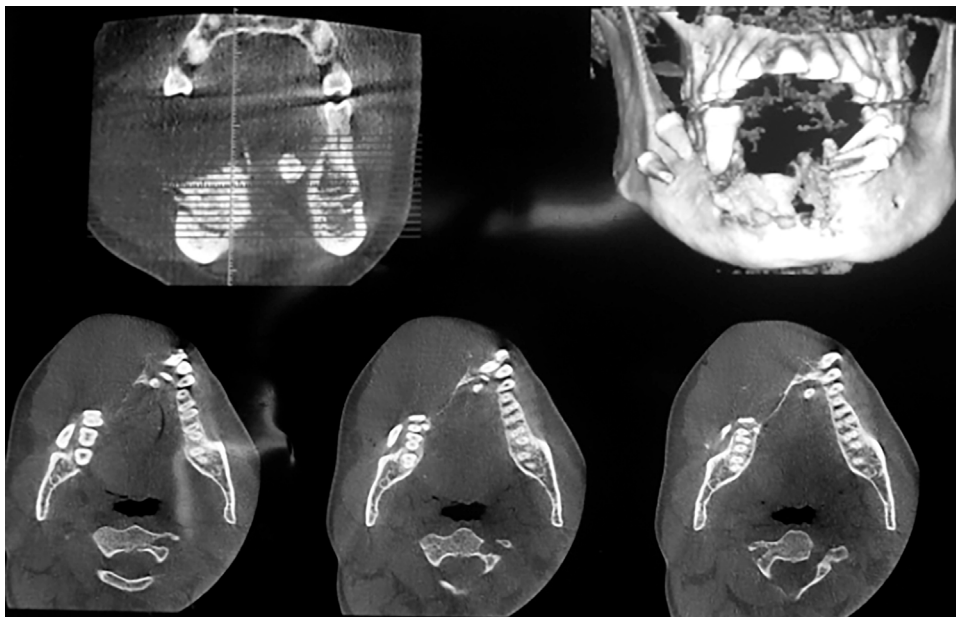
The CBCT scan revealed a lytic expansile mass in the anterior and right posterior mandible.
